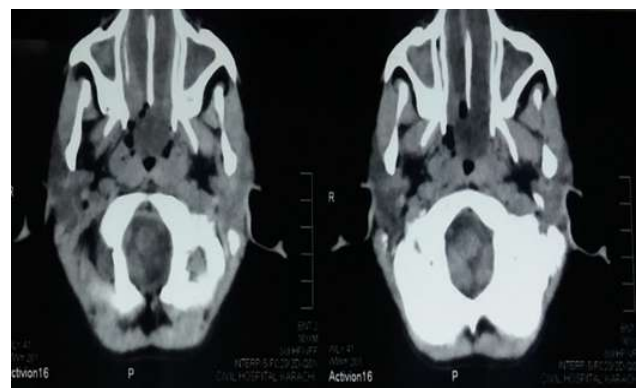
CT Scan of the nose and PNS in axial view showing similar findings
